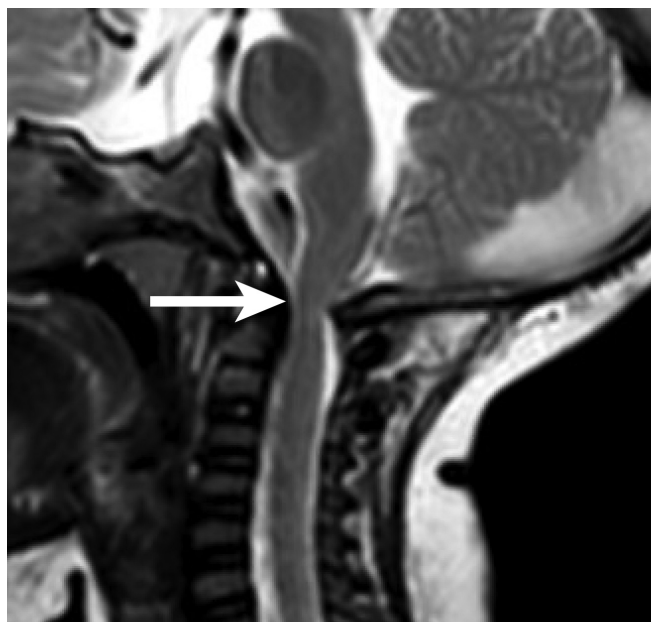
Sagittal T_2 -weighted magnetic resonance image of the neck of our patient at 10 months, showing opisthion hypertrophy with resultant severe compression at the craniocervical junction (white arrow).
